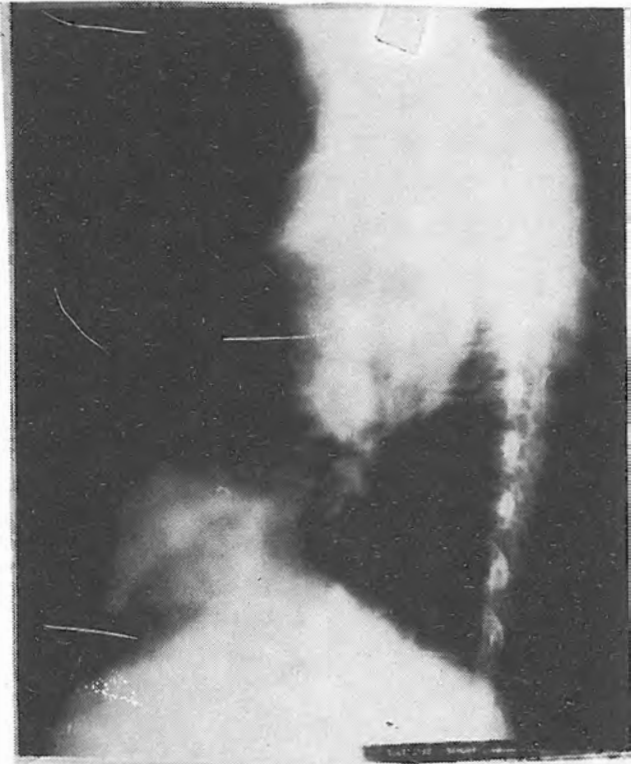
Lateral chest roentgenogram of large posterior mediastinal goiter
